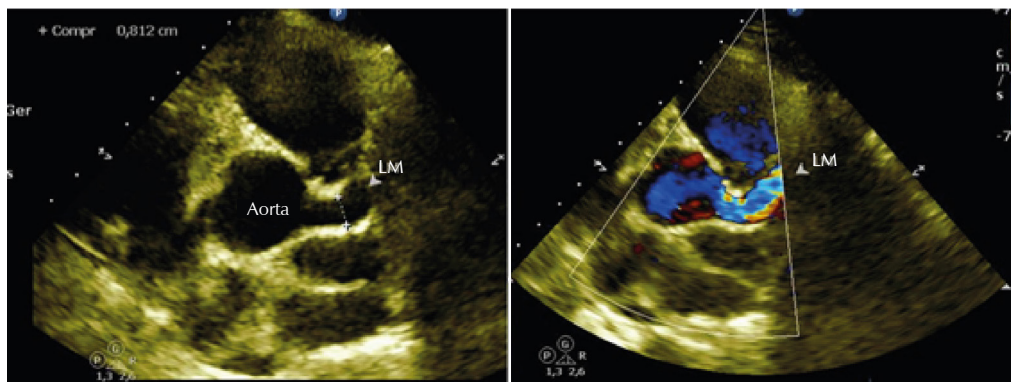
Transthoracic echocardiography (short-axis imaging plane at the level of the base vessels). Left coronary artery trunk dilated to two-dimensional and demonstration of turbulent flow on color Doppler.
